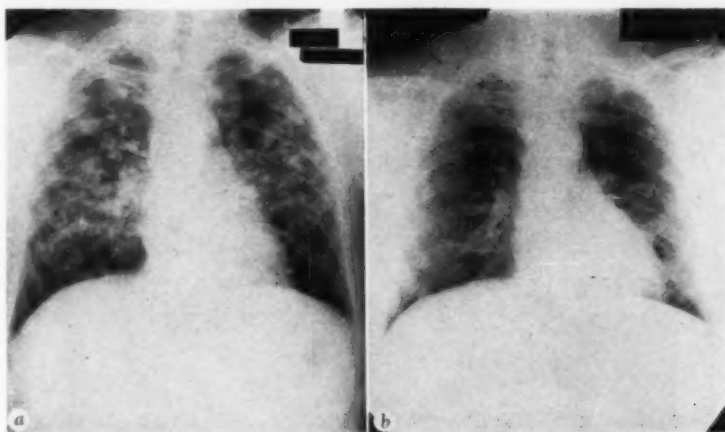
a.* Roentgenogram showing atypical appearance of the thorax in case of primary pulmonary histiocytosis X (case 3). *b.* Same patient after 12 months of treatment with prednisone.
